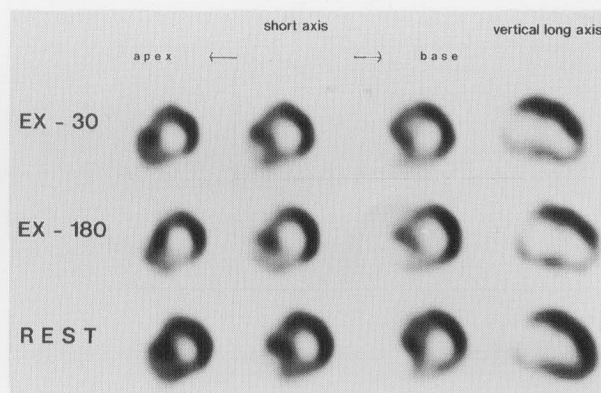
Tc-99m-tetrofosmin SPECT images in a 56-year-old man with hypertrophic cardiomyopathy. Decreased uptake is observed in the septal portion of the anterior and posterior walls, the apex and the postero-inferior walls in the EX-30 images. In the EX-180, reverse redistribution is seen in the same segments and the septum.
